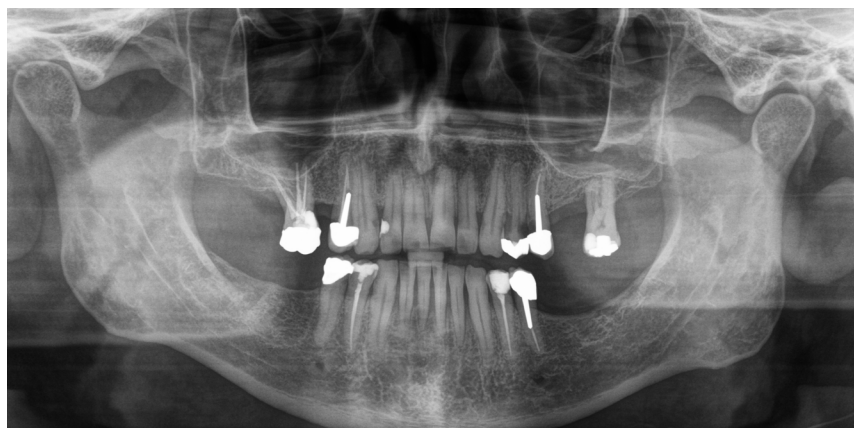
Ortho-panoramic X-ray examination (OPT) 2019 at BL – Patient S. J. – d.o.b. 05/19/1958
